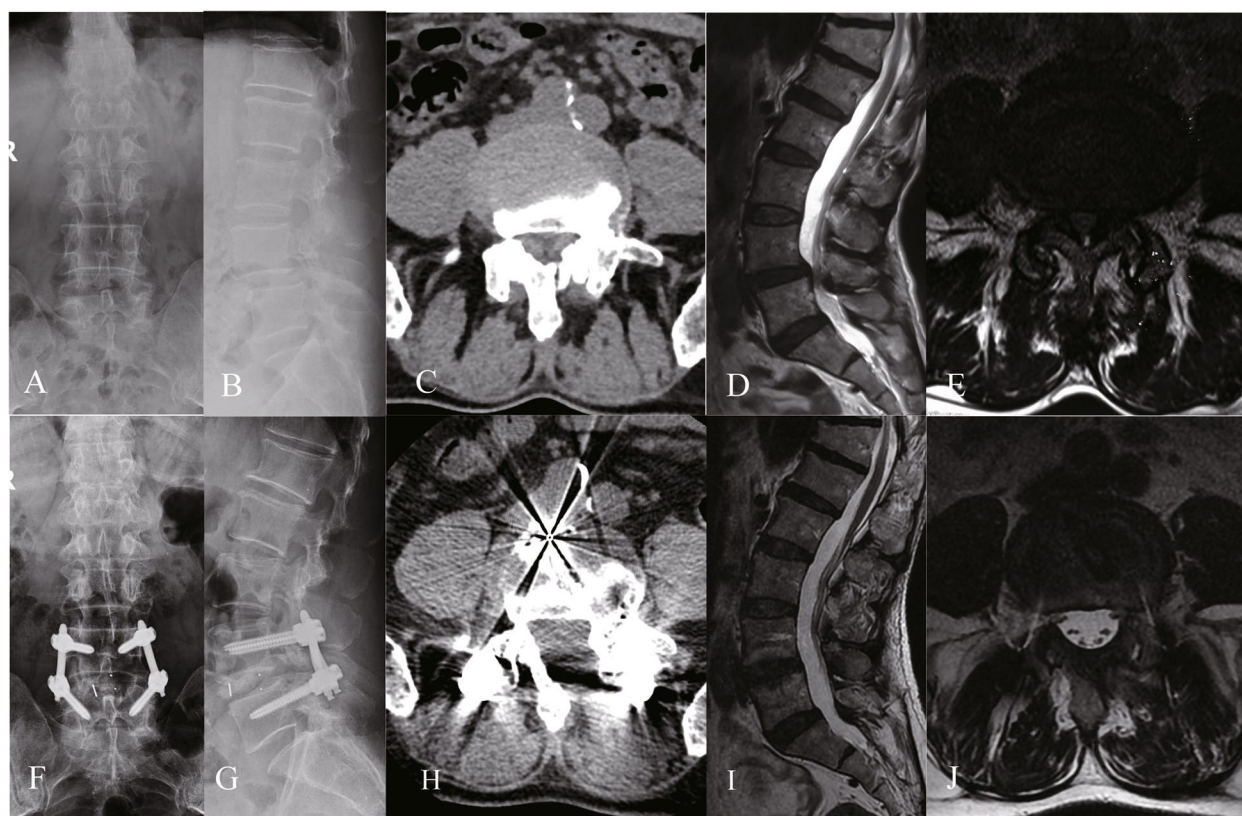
A 60-year-old female patient who underwent ULIF surgery. A, B Preoperative antero-posterior and lateral radiographs. C Preoperative transverse CT scan. D, E Preoperative sagittal and axial T2-weighted MR image; (F, G) Postoperative antero-posterior and lateral radiographs; (H) Postoperative CT scan. (I, J) Postoperative sagittal and axial T2-weighted MR images
